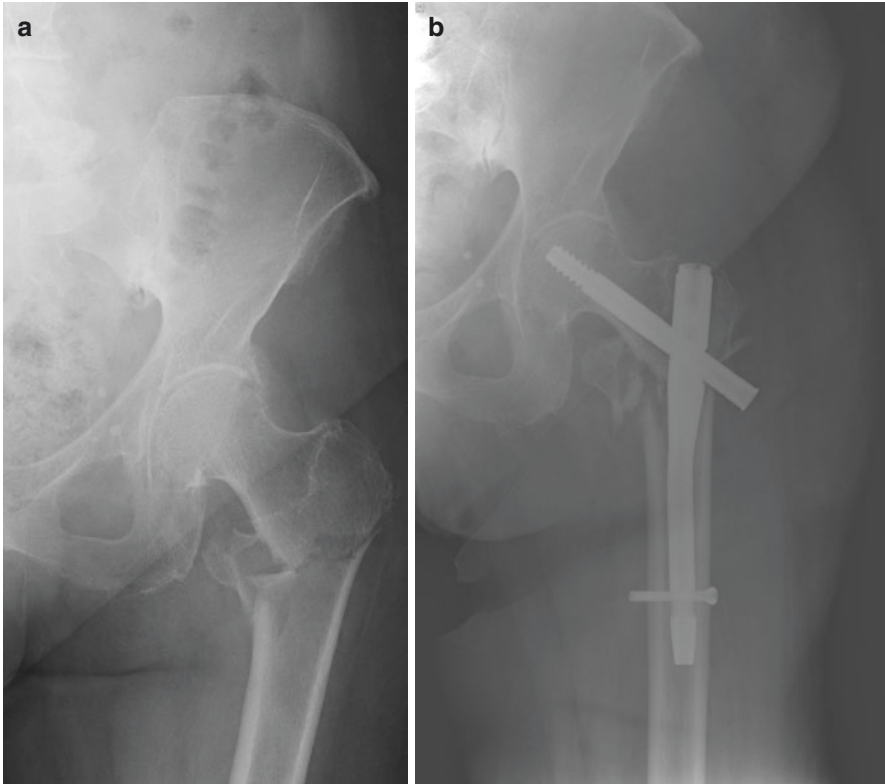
(a) AP radiograph of a left hip demonstrating an unstable intertrochanteric hip fracture. The posteromedial cortex is comminuted. (b) AP radiograph after treatment with a short cephalomedullary nail. Note the amount of fracture impaction or “slide” with this unstable pattern
